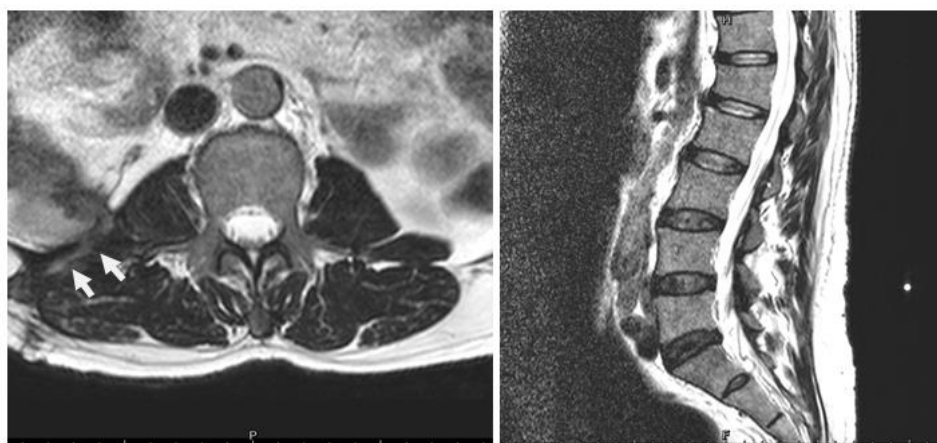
Hyperintense changes on T2-weighted images in the psoas muscle with a small fluid tract (white arrow) communicated with lumbar skin. No spondylodiscitis could be seen.
